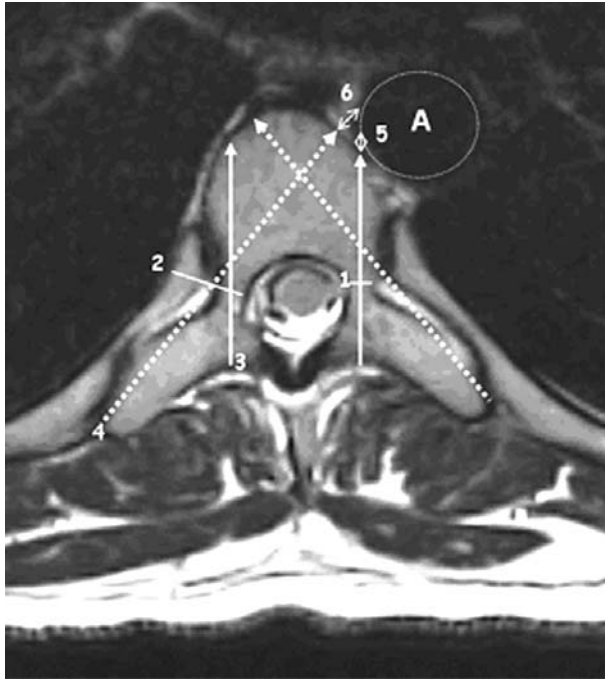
T1-weighted axial magnetic resonance image demonstrating the manner in which the width of transverse intraosseous pedicle(1), the width of transverse intraosseous pedicle-rib unit(2), the length of pedicle screw path(3), the length of pedicle-rib unit screw path(4) were measured. The distance of pedicle screw path to aorta(5) and the distance of pedicle rib-unit to aorta(6) were measured from the outer aspect of the the wall of aorta (A) to the nearest of the vertebral body.
